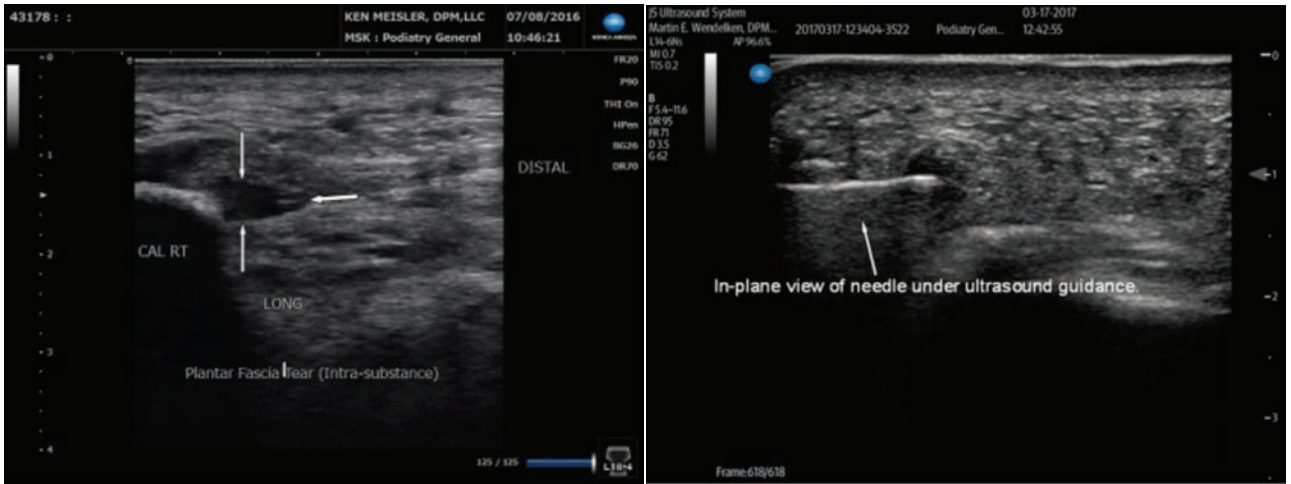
Upper Left: Image of the plantar fascia longitudinal axis reveals anechoic area representing an intra-substance tear at the attachment of the fascia on calcaneus. Upper Right: A transverse image of an ultrasound guided injection of the plantar fascia. This is an in-plane view of the needle that is noted in the mid-field of the scan. Note the anechoic area at the needle tip showing denoting the fluid exiting the distal tip of the needle.
